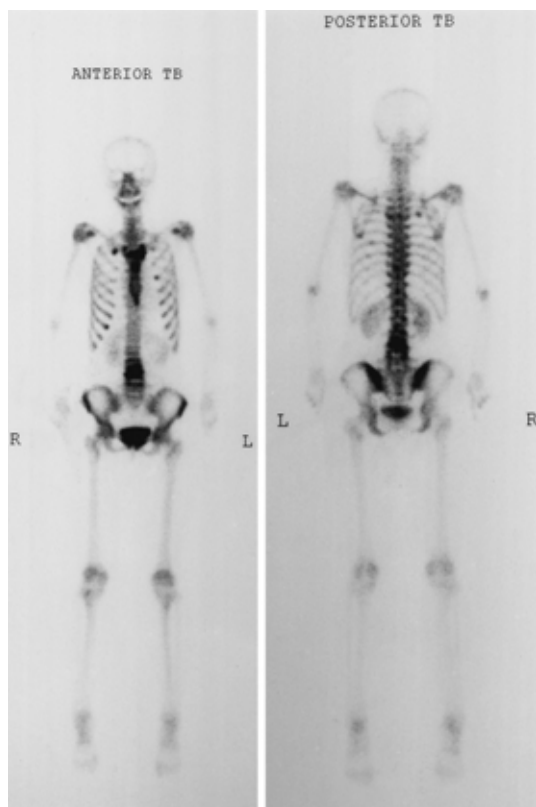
Bone scintigram. Technetium bone scintigram shows increased uptake in L3-4 vertebral bodies and upper end of sternum
